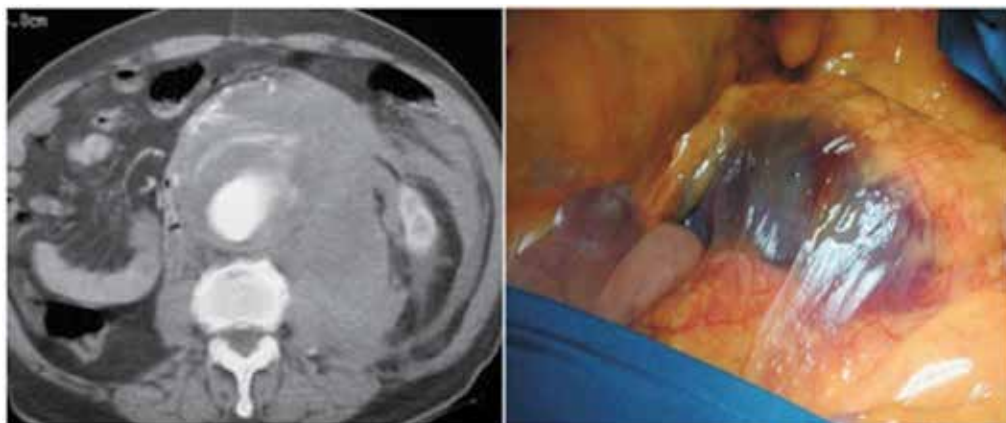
Preoperative angio-CT showing a RAAA (panel A), and the intraoperative finding (panel B).
